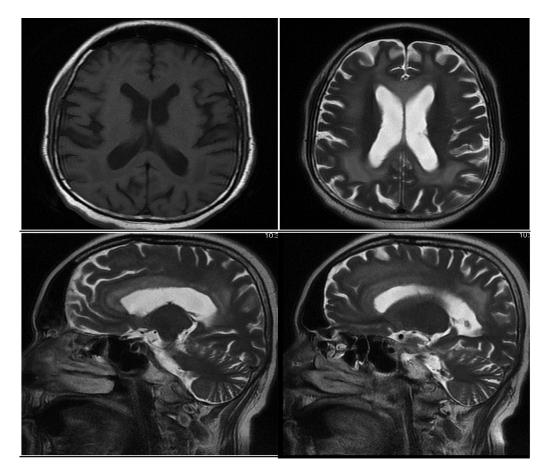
In a 45-year-old chronic alcoholic patient presented with seizures, altered sensorium, and bilateral lower limb paresis, T1W (upper row right) image shows hypointense corpus callosum and periventricular white matter with corresponding T2 (upper row left and middle row) and FLAIR (lower row right images shows hyperintense signal with true restricted diffusion in DWI image (lower row left). There is no postcontrast enhancement seen (last image).
